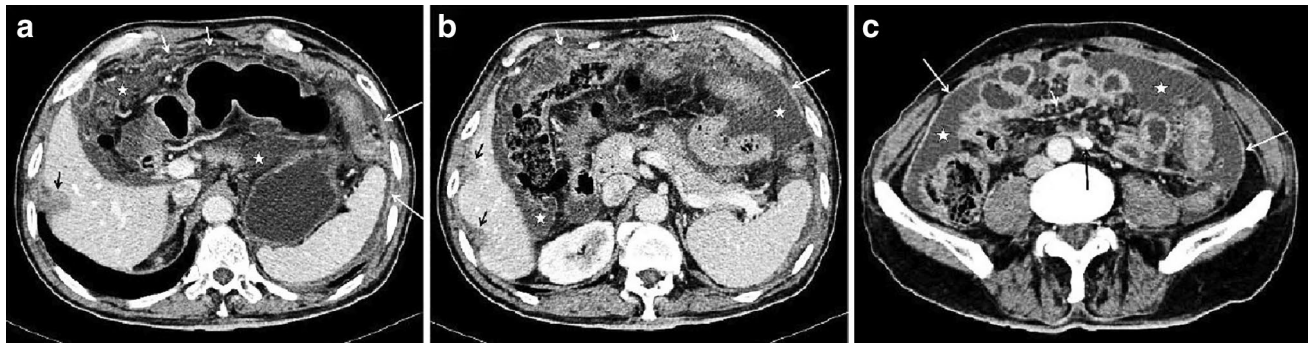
Axial CT section through the abdomen in the venous phase in a 67-year-old man with PTB. a, b, c Smooth thickening of the peritoneum (long white arrow), smudged thickening of the omentum (short
